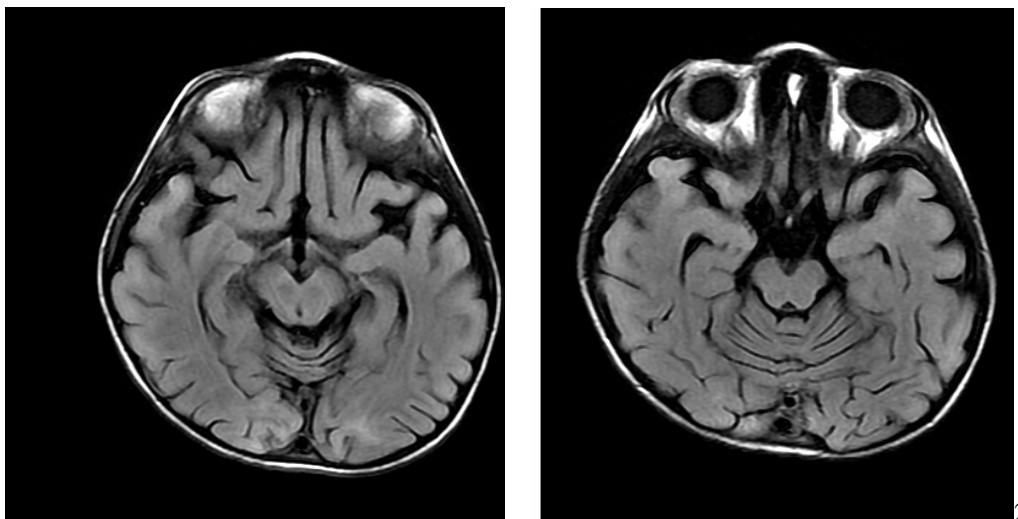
Bilateral symmetrical high signal foci on FLAIR that are seen at cerebellum peduncle of uncertain significance
